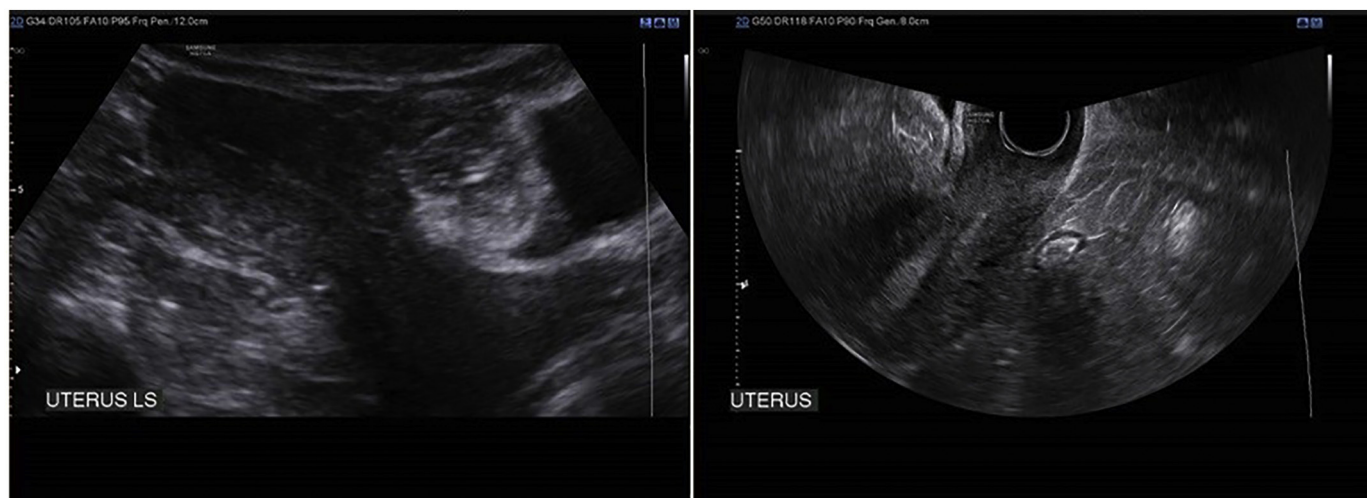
Transabdominal ultrasound scan and TVS showing resolution of CSD.
